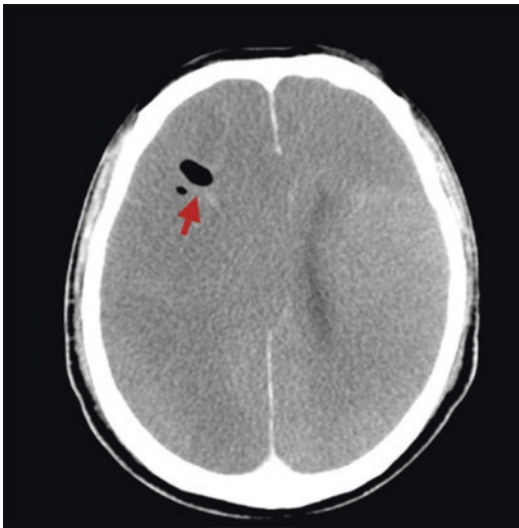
Axial brain computed tomography image of a case with a fatal cerebral gas embolism. Intraparenchymal gas due to the gas embolism can be seen (arrow). Furthermore, there is cerebral low density in the right hemisphere and in the left anterior cerebrum due to infarction caused by gas emboli
